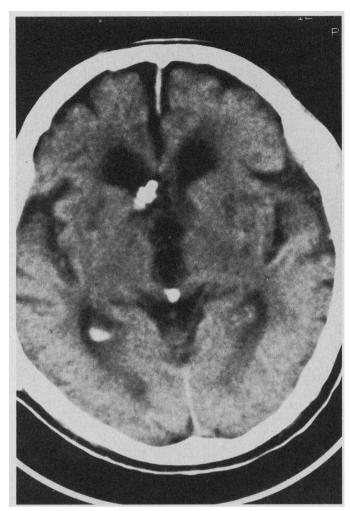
Case 1. Computed tomographic scan showing catheter tip in septum verum.
